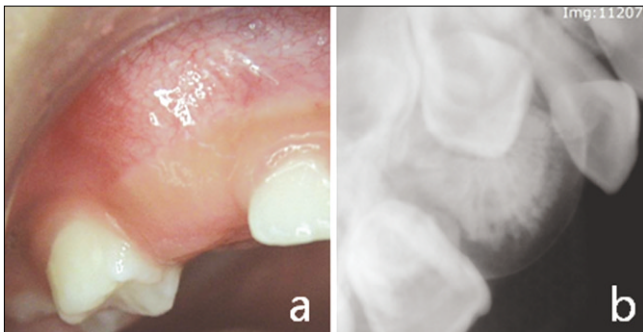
Intraoral view(a), periapical view(b) at the first visit.
